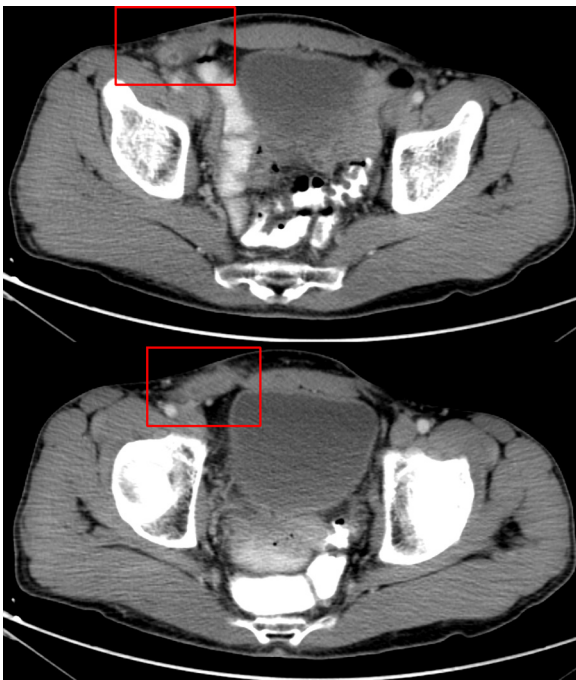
CT scan images. A tubular structure in the right inguinal canal can be seen.
